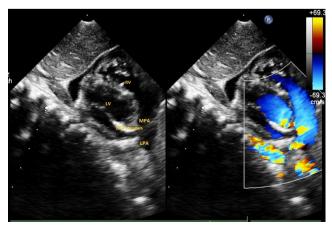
2D echocardiography with color Doppler showing bilateral PAS.
